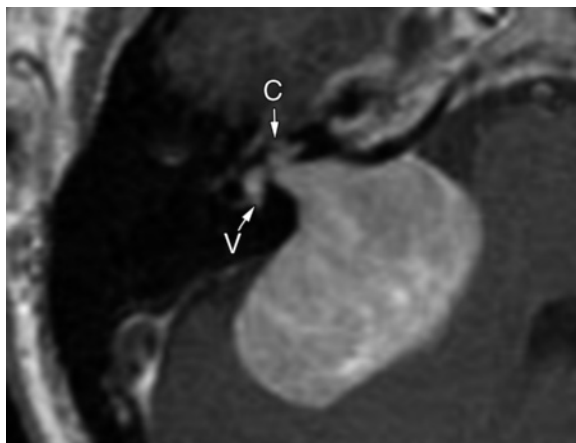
Vestibulocochlear schwannoma. Axial fat-saturated T1-weighted MR image shows a schwannoma that extends into the cochlea (C) and vestibule (V). In such a case, the schwannoma can be addressed only with a translabyrinthine approach.
